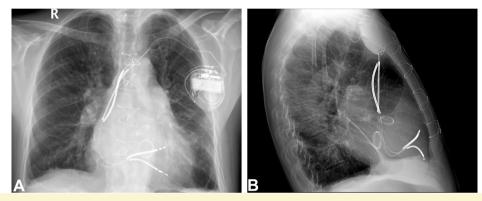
Chest x-ray images showing the new implantable cardioverter-defibrillator system with preexisting fractured lead in situ in the posteroanterior (A) and lateral (B) views.
